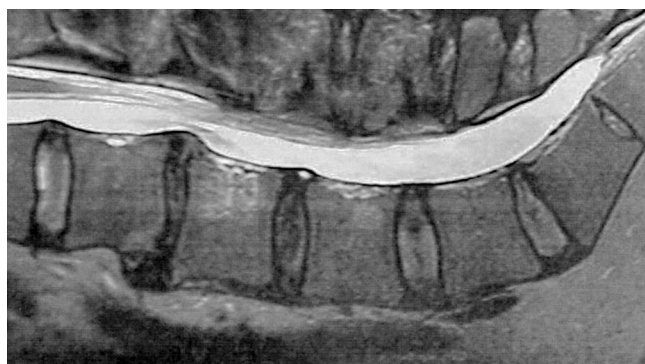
Sagittal T2-weighted MRI demonstrating loss of disc space height and decreased T2 signal intensity at the L2–L3 interspace.
